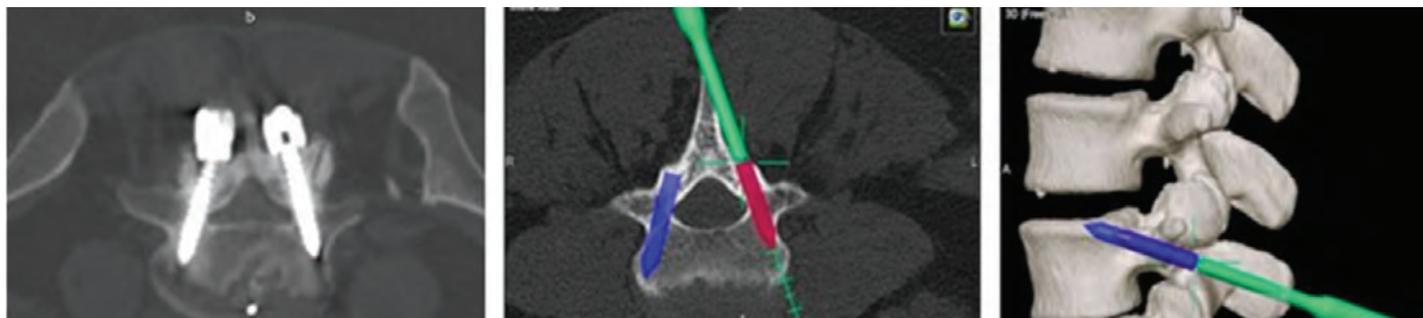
Neuronavigation guidance of the CBT pedicle screws (right and centre) and the postoperative CT control of the screw position (left).
